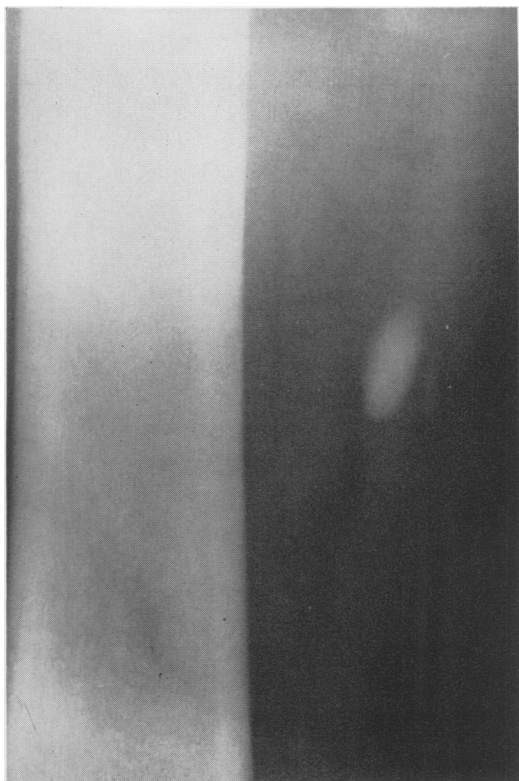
Five minutes after the Hypaque injection the main channel of the vein is almost cleared. There is still good concentration in the backwater of the valve pockets. Further x-rays showed that the pockets were not empty until 12 minutes after the injection.
